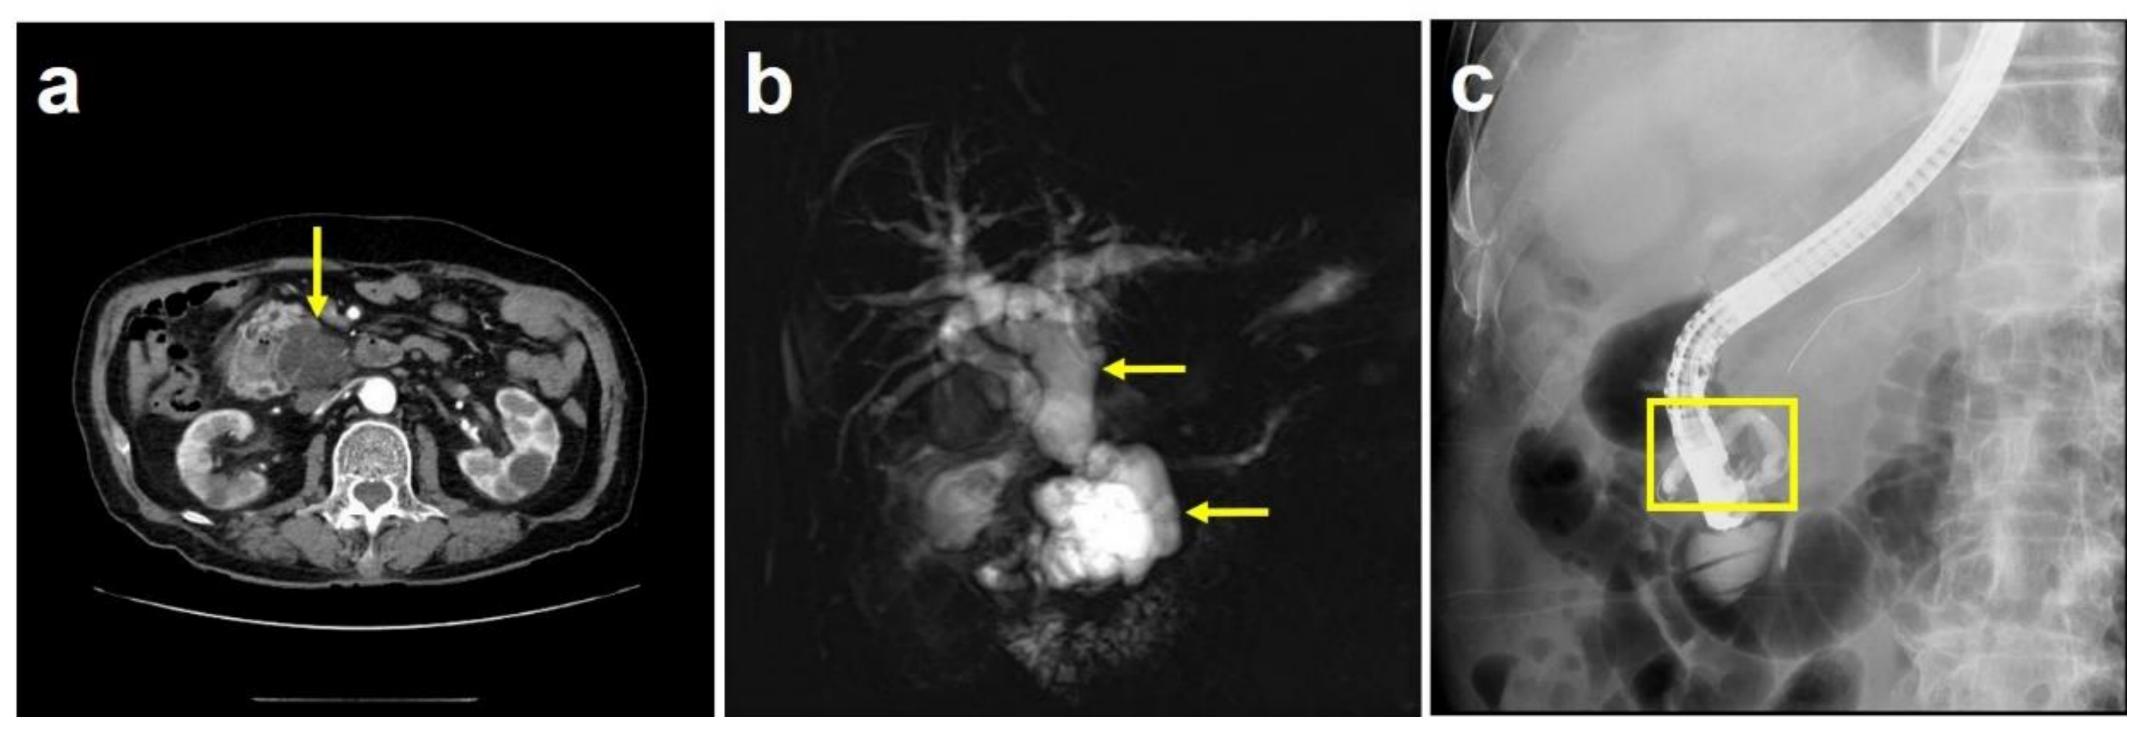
(a) Abdomen CT : Arrow indicates a huge IPMN (6 cm sized multi-locular mass) at pancreatic head. (b) Abdominal MRI with MRCP. The upper arrow indicates a diffuse common bile duct dilatation. And the lower arrow indicates a suspicious annular pancreas. (c) Endoscopic retrograde cholangiopancreatography Encircling ventral annular pancreatic duct (diameter 7mm) was connected to dorsal pancreatic duct using guidewire and contrast dyes.
